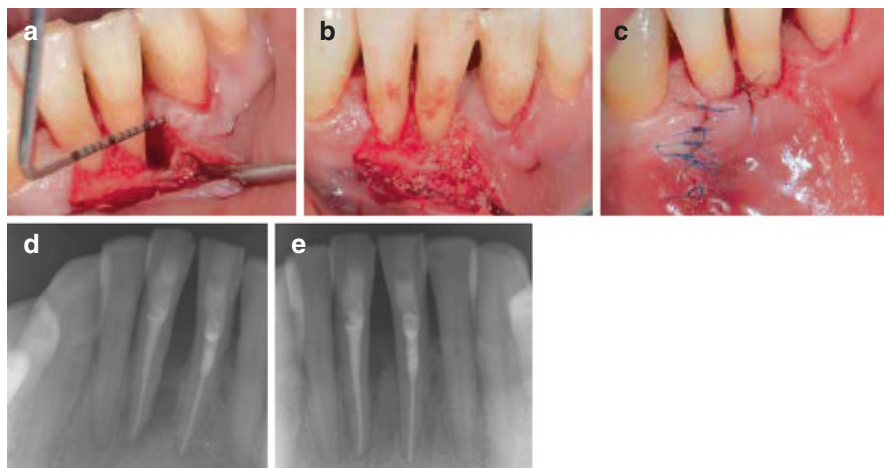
Case 2: entire papilla preservation technique. (a) Incision design gaining access to the infrabony defect on the mesial of the mandibular right central incisor. (b) Application of EMD and bone substitute into the infrabony defect. (c) Primary wound closure of the surgical site. (d) Presurgical radiograph of infrabony defect on the mesial of the mandibular right central incisor. (e) Postsurgical radiograph of bone fill within the infrabony defect
